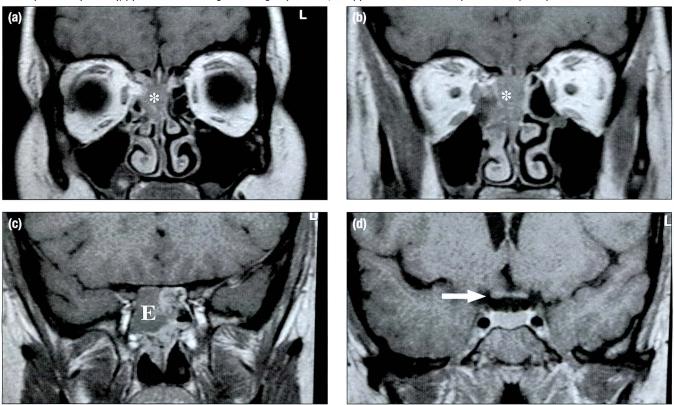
T1-weighted gadolinium-enhanced magnetic resonance image at presentation showing (a and b) the mass in the right anterior ethmoidal sinus (asterisk), extending to touch the right medial rectus muscle; (c) mass and fluid in the right posterior ethmoid sinus; and (d) the optic chiasma (arrow) with no disease around it.
